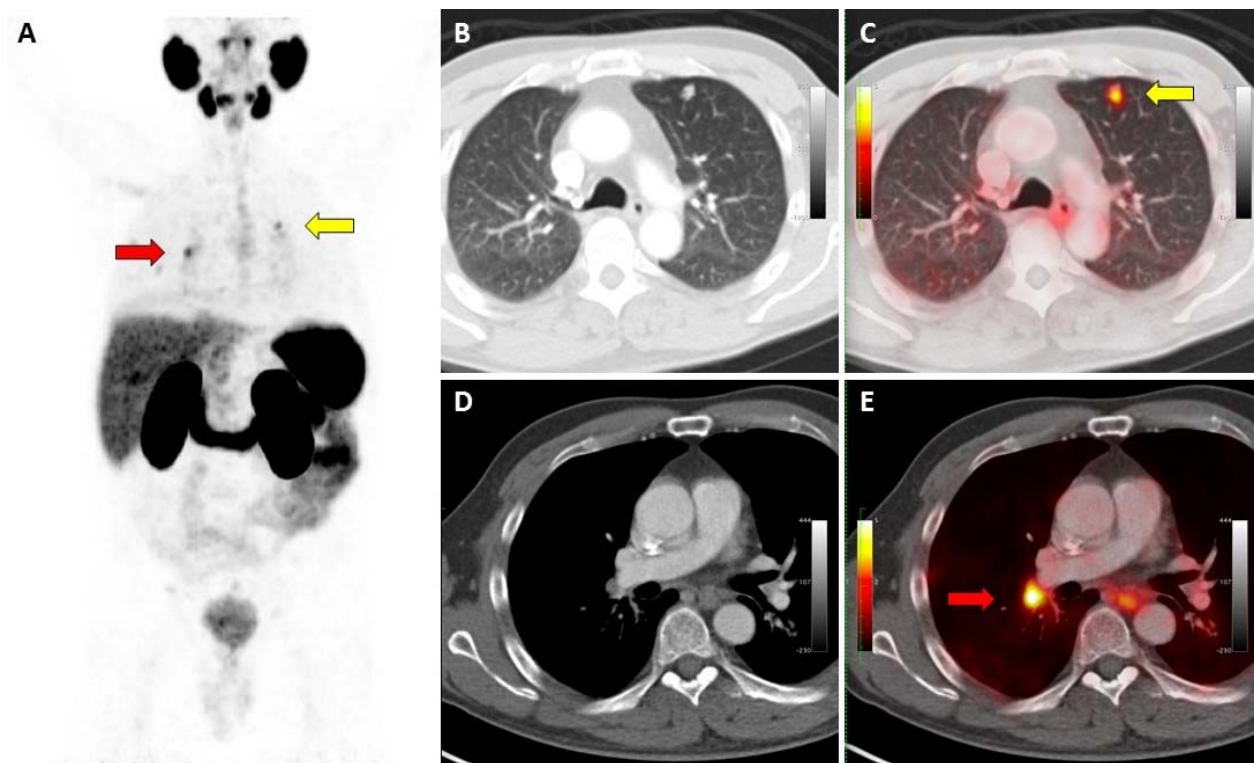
67-year-old man with BCR (PSA 10.7 ng/ml, doubling time 9.3 months) of an initially high-risk prostate cancer (Gleason 9; pT3a) eight years after primary radical prostatectomy and adjuvant prostate bed irradiation. The intended pre-scan treatment was ADT. PSMA-11 PET/CT showed intense PSMA-11 uptake (SUVmax 7) in multiple lung nodules (yellow arrows) and thoracic lymph nodes (red arrows). The intended post-scan treatment (Q2) was chemotherapy + ADT. The CT-guided biopsy of the upper left lung nodule confirmed metastatic prostatic adenocarcinoma. Patient elected to forgo chemotherapy because of the potential side effects and thus the intended post-scan management (Q2) was not implemented. The actual management was ADT alone and thus there was no change from the pre-scan intended management as recorded on Q1.
